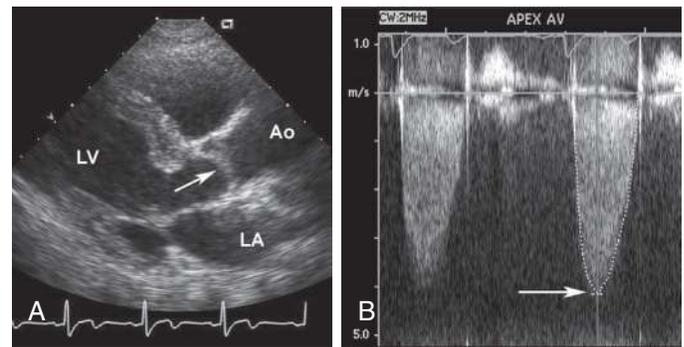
A, In this 26-year-old pregnant woman with a loud systolic murmur, the long-axis view shows doming of the aortic valve in systole (*arrow*). Short-axis images confirmed a unicuspid aortic valve. B, Continuous-wave Doppler examination of the aortic valve demonstrates a high-velocity signal consistent with severe aortic stenosis. The maximum velocity of 4.2 m/sec corresponds to a maximum transaortic pressure gradient of 69 mm Hg and a mean gradient of 41 mm Hg. Valve area, calculated by the continuity equation, was 0.8 cm². Ao, Aorta; LA, left atrium; LV, left ventricle.
